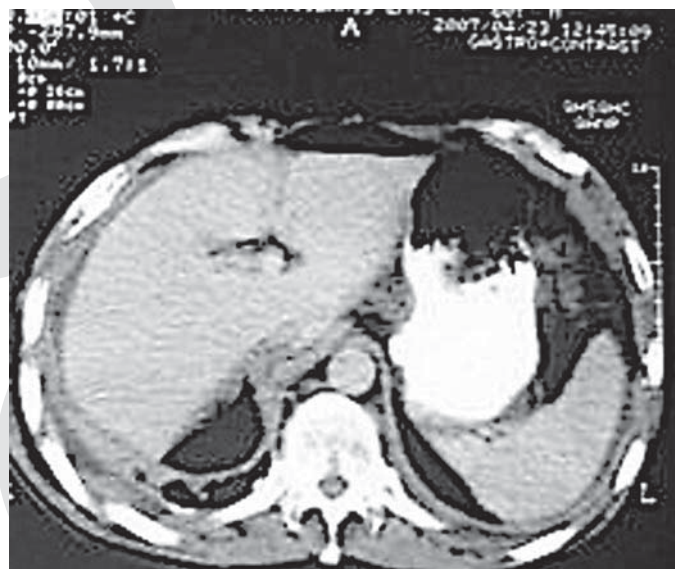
Patient's abdominal computed tomography in April 2007, showing important improvement in the ascites.
